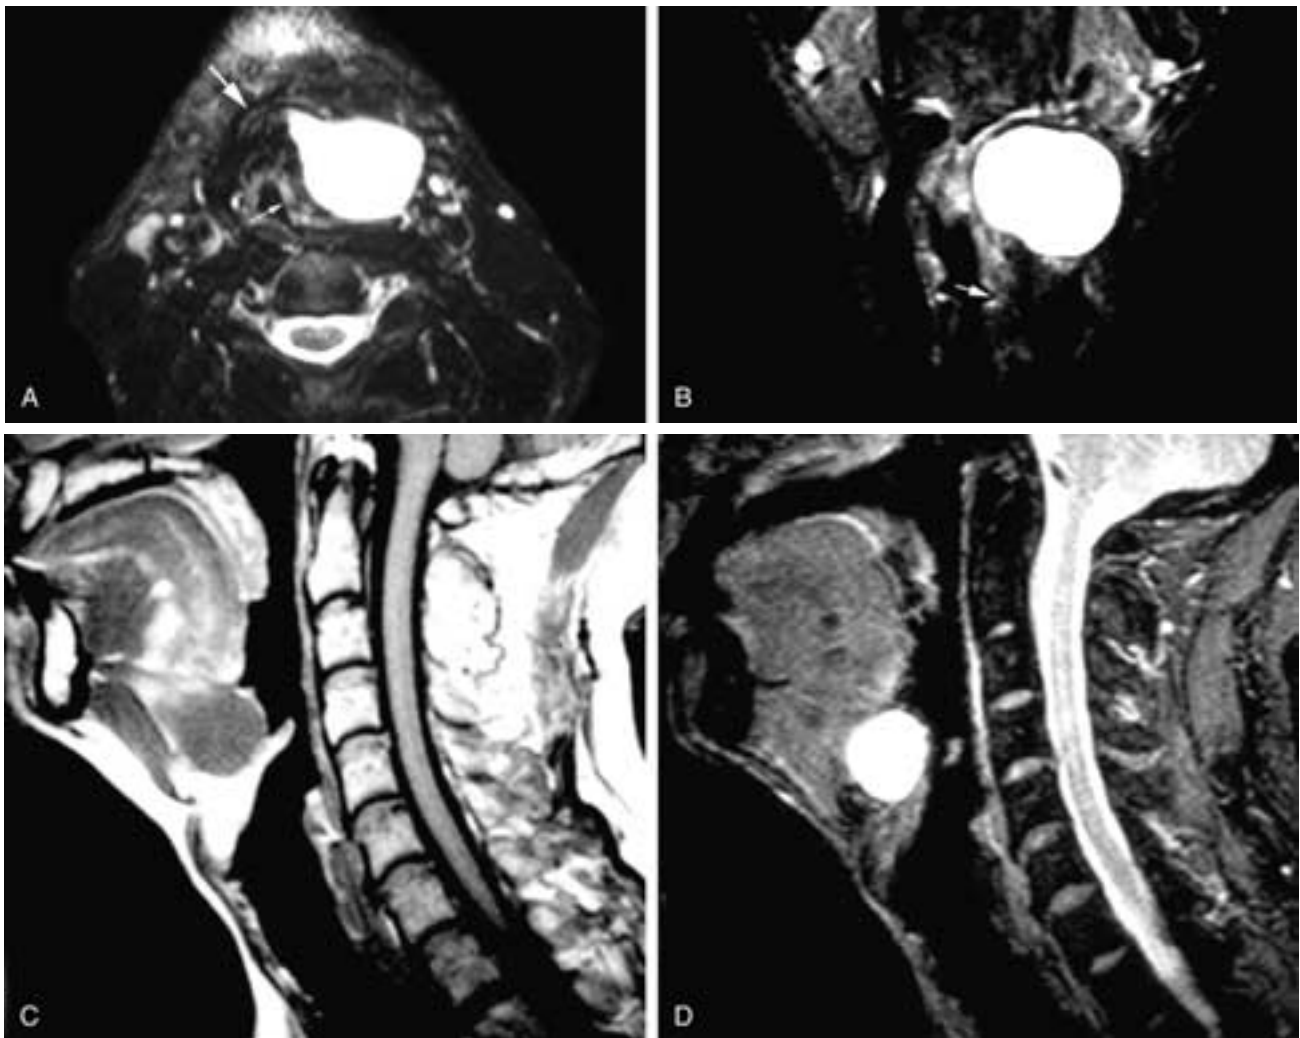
Axial (A) and coronal (B) T2-weighted MR images on a patient clinically thought to have a large submucosal laryngocele. In A, this high-attenuation cyst is seen to be in relationship to the dorsal aspect of the hyoid bone (*large arrow*) and to displace the supraglottic mucosa (*small arrow*) medially. In B, the cyst is seen to be cranial to the laryngeal ventricle (*arrow*), with no connection to the ventricle or any laryngeal appendix. This was a large thyroglossal duct cyst. Sagittal T1-weighted (C) and T2-weighted (D) MR images show a cyst in the vallecula with low T1-weighted and high T2-weighted signal intensity. This cyst is on the mucosal surface of the pharynx, and it is not within the tongue base. This is a vallecular or retention cyst, and its location is common for such cysts.
